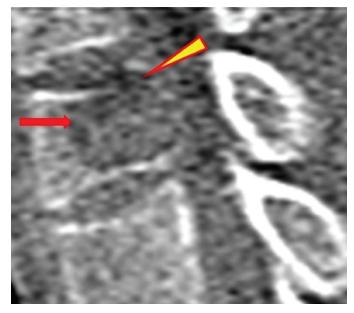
Vertebral giant cell tumor. Sagittal, CT scan of lumbar vertebra shows expansile vertebral body lesion with narrow, nonsclerotic transition zone (*arrow*) and some cortical breaching (*arrowhead*).
